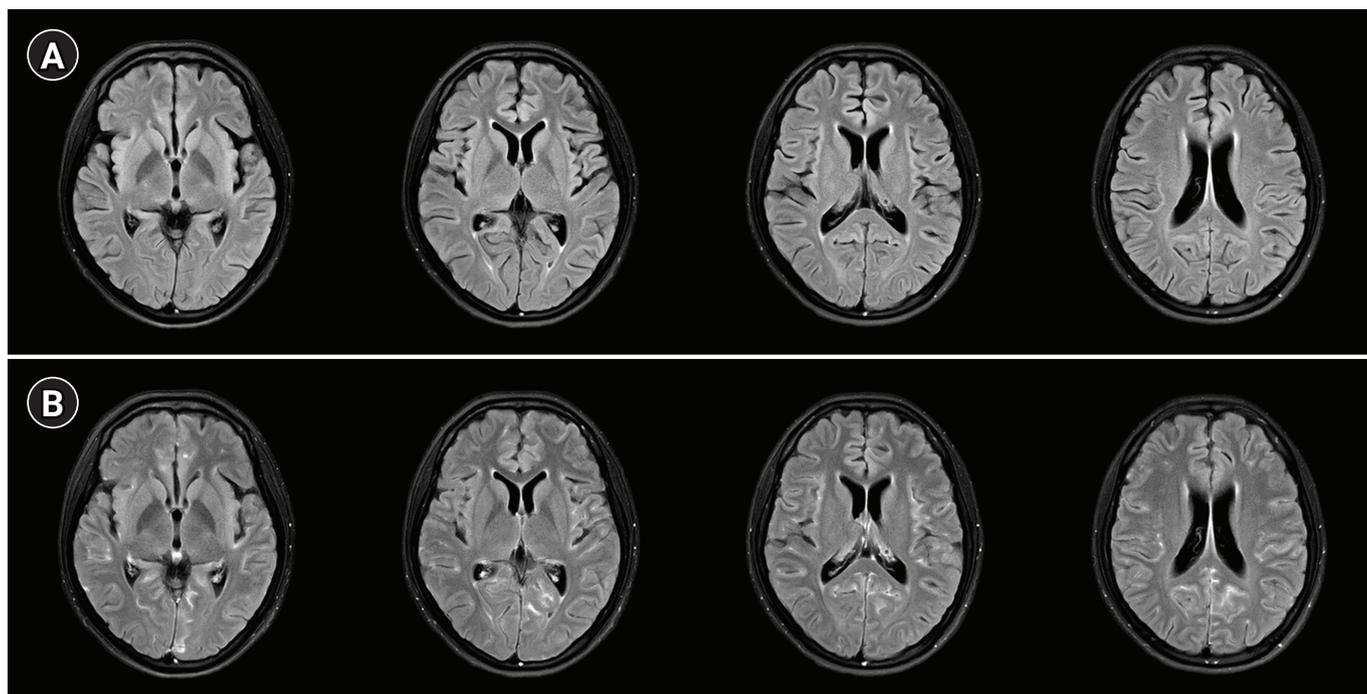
Initial brain magnetic resonance imaging. (A) Fluid-attenuated inversion recovery (FLAIR) image revealed no abnormal signal intensities. (B) FLAIR-enhanced image revealed multifocal sulcal enhancement in the cortical sulcus, suggesting lupus meningitis.
